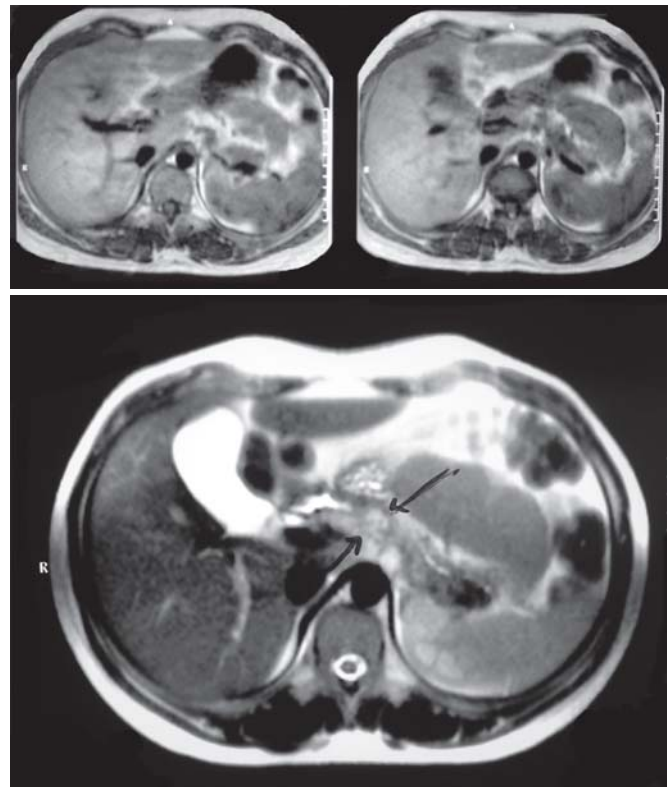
MRI showing a lesion in the mid-body of the pancreas on T2-weighted images
